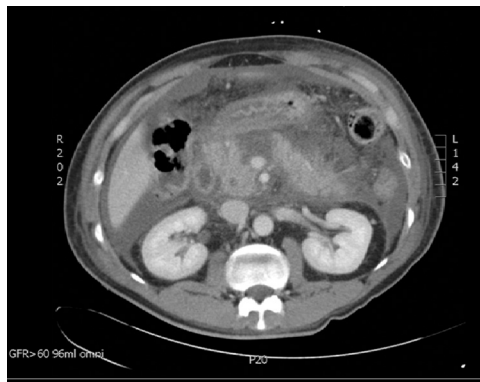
Enhanced CT scan of necrotizing pancreatitis.
